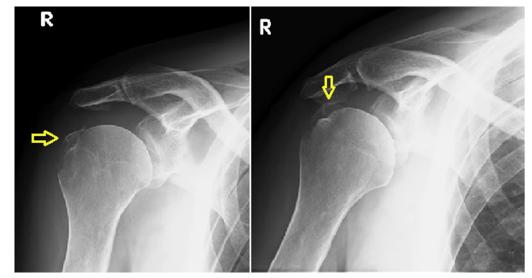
Radiograph of the right shoulder showing a greater tuberosity displaced avulsion fracture.
